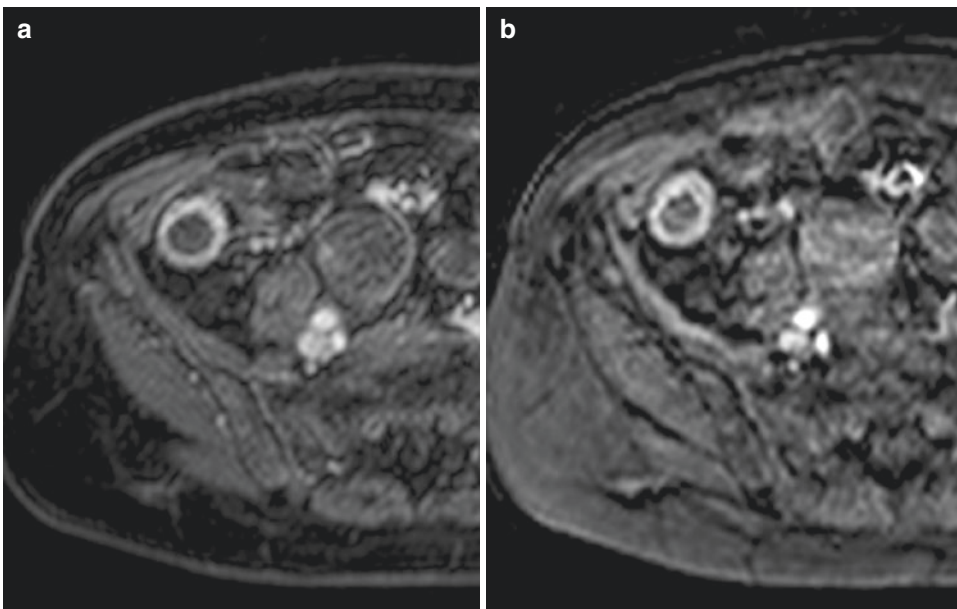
Comparison of 2D and 3D GE T1-weighted sequences in a patient with active Crohn's disease of terminal ileum. Axial 2D GE T1-weighted image (a), and axial 3D GE T1-weighted image (b) with fat suppression
